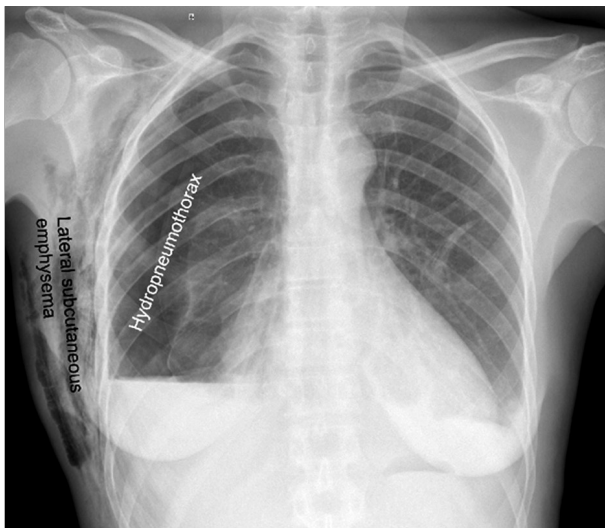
Postoperative chest radiography showing hydropneumothorax and subcutaneous emphysema
